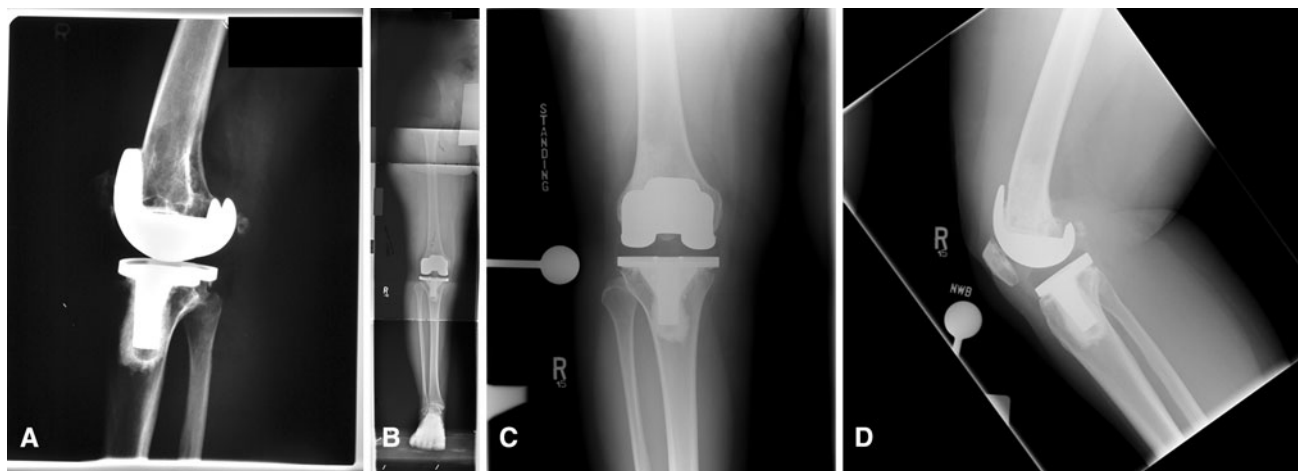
Radiographs of a 45-year-old woman who underwent liner exchange and bone grafting of a femoral osteolytic lesion are shown. (A) The prerevision radiographs are shown; (B) the postrevision lower limb alignment view; (C) the 7-year postrevision
